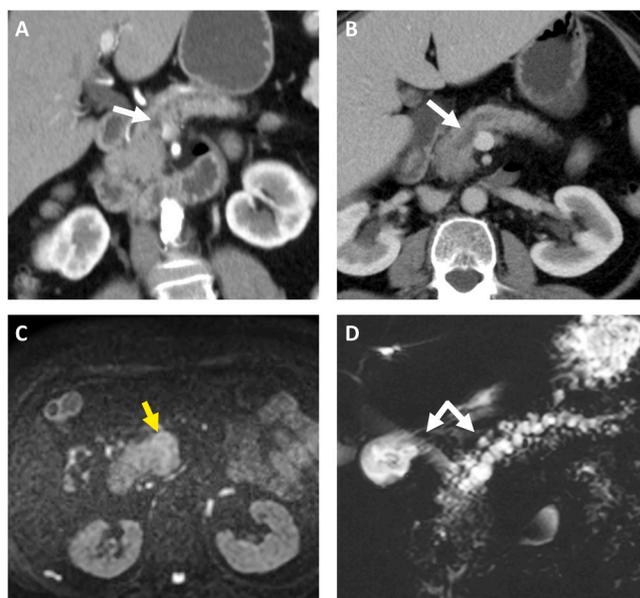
Isodense PDAC. This patient presented with dilated main pancreatic duct (A and B, white arrows) and slightly dilated biliary tree, but a pancreatic tumor was not clearly seen on CT on both pancreatic (A) and portal venous (B) phases. MRI clearly identifies the obstructing tumor in the pancreatic head, as observed on DWI (C, yellow arrow) and a double duct sign on MRCP (D, white arrows).
